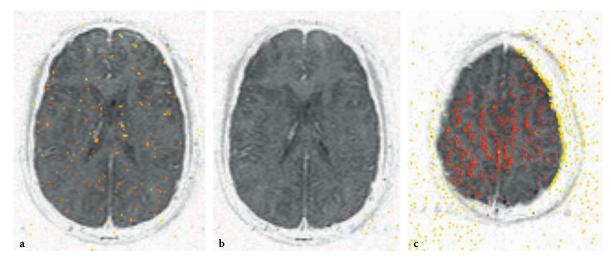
Functional MRI experiment using a block paradigm. In this case the subject is at rest throughout the experiment. Apparent areas of significant activation (a) which disappear after coregistration (b). Activations (c) in a synthetic data set constructed from multiple identical copies of the baseline image. These copies were then coregistered to mimic exactly the movements made by the subject during the actual experiment. These data appear to generate multiple areas of highly significant activation that are entirely due to coincidental stimulus correlated motion. The activations are far greater than seen in the real data only because the noise structure in the synthetic images is identical in each image
